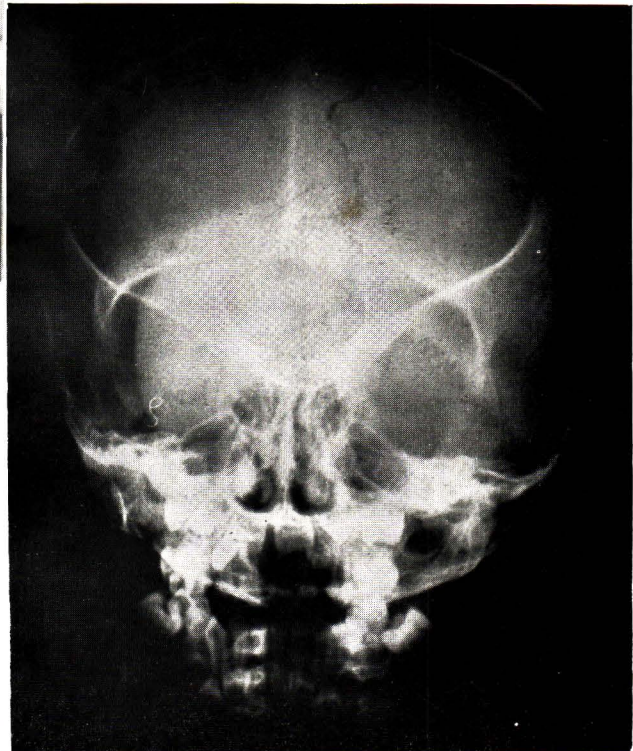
Nasofrontal type of frontoethmoidal encephalomeningocele, postero-anterior roentgenogram showing the cranial defect.
